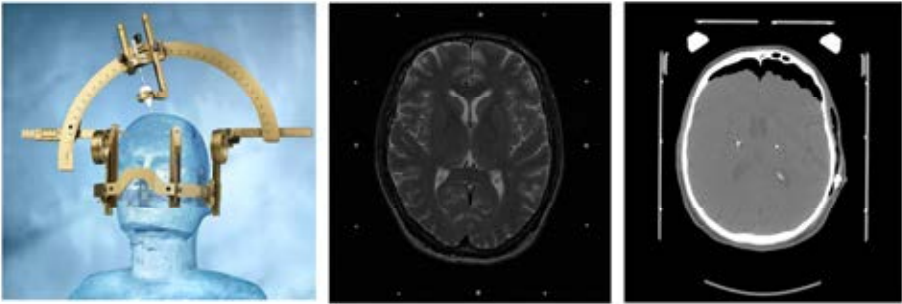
Stereotactic implantation of DBS electrodes. A stereotactic frame is placed on the head of the patient, and a stereotactic arc is used for the electrode insertion, as seen in the left image (Courtesy of Elekta Instrument AB, Sweden). The middle image shows a preoperative MRI image with stereotactic reference coordinates, seen as bright spots. The right image shows a postoperative stereotactic CT, where the inserted DBS electrodes are visible as bright artefacts.
